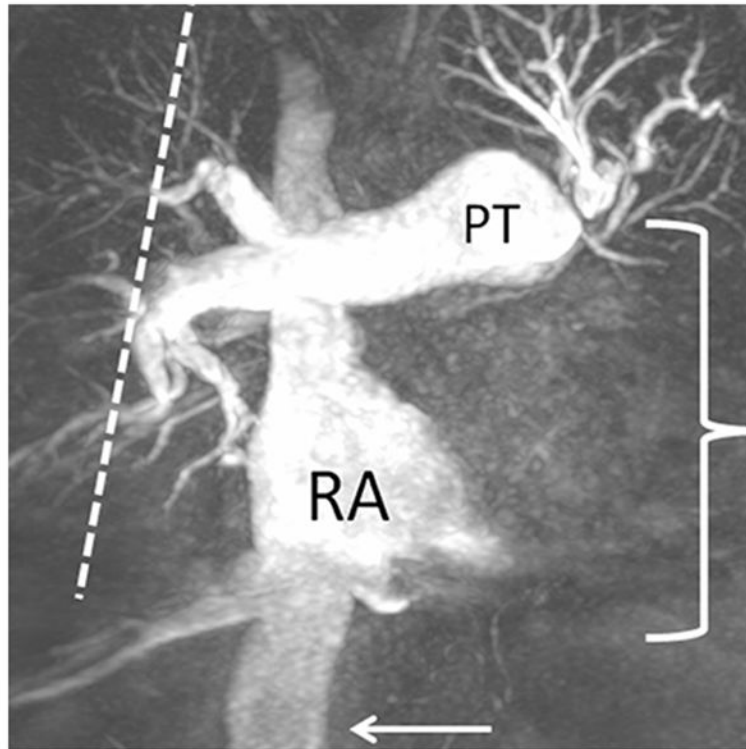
Cardiac MRI of pulmonary hypertension
